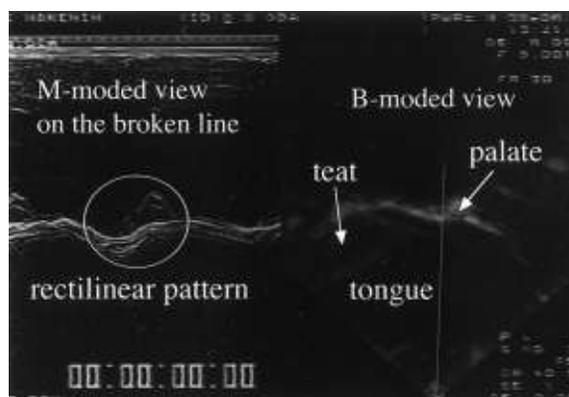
The rectilinear pattern on M-mode ultrasonography which indicated sequential changes in the volume of the space formed by the tongue, palate, and nipple during nutritive sucking.
